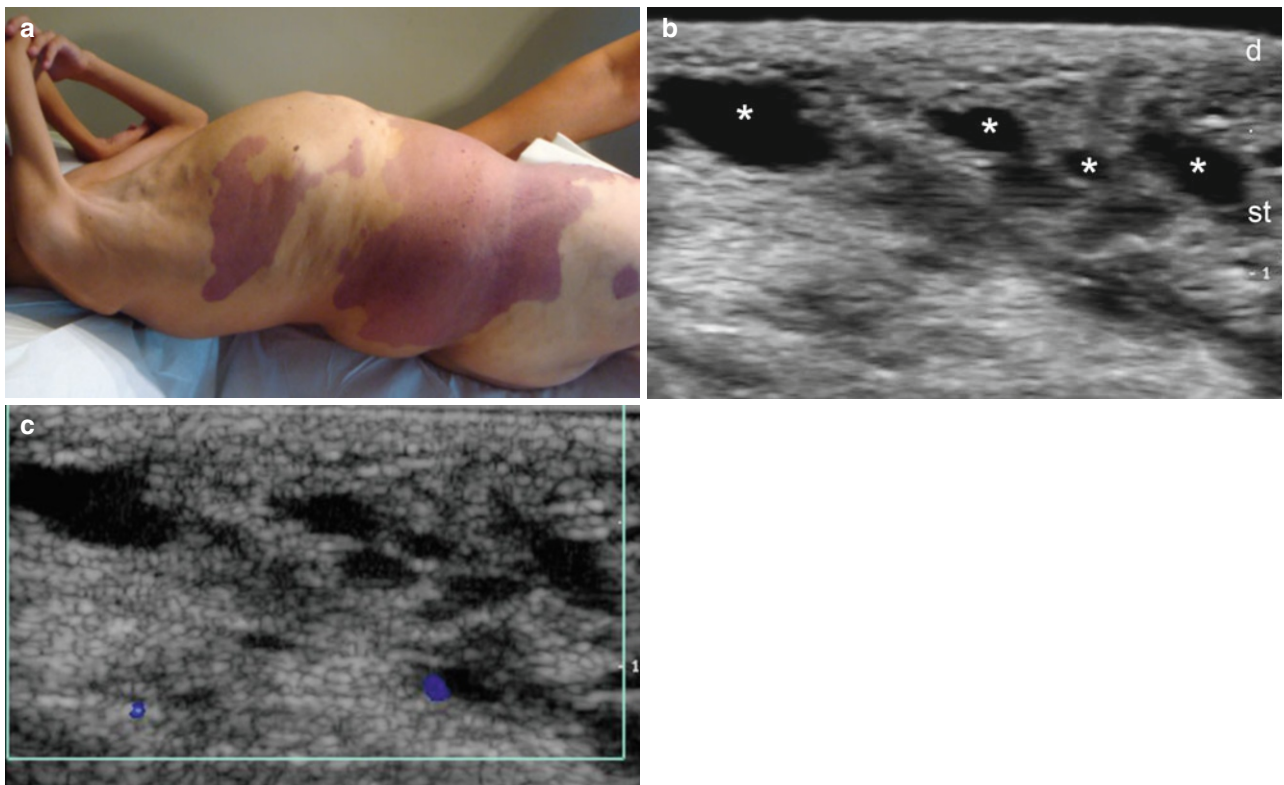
(a-f) Venous vascular malformation in Proteus syndrome. (a) Clinical image of a patient with Proteus syndrome. (b) Ultrasound image (gray scale, transverse view at the right thoracic region) shows multiple anechoic pseudocystic structures (*) in the subcutaneous tissue. (c) Color Doppler ultrasound image (transverse view, right thoracic region) demonstrates scarce flow within the pseudocystic areas. (d) Color Doppler spectral curve analysis shows low monophasic venous
